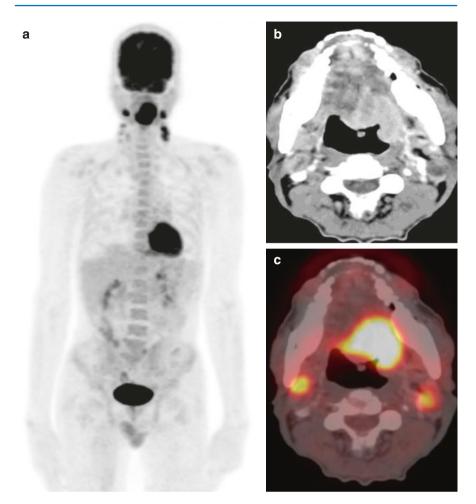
The use of FDG PET CT for initial staging in a patient with a T4 squamous cell carcinoma of the left oropharynx. FDG PET CT revealed metastasis to the bilateral cervical lymph nodes and liver, thereby triaging the patient toward palliative chemotherapy. (a) PET Image showing primary tumour in left posterior tongue and retromolar trigone with metastasis to bilateral cervical lymph nodes and liver. (b) Transaxial PET CT image showing primary tumour in left posterior tongue and retromolar trigone. (c) Transaxial PET CT Image showing hypermetabolic metastatic nodule in segment VI of the liver
